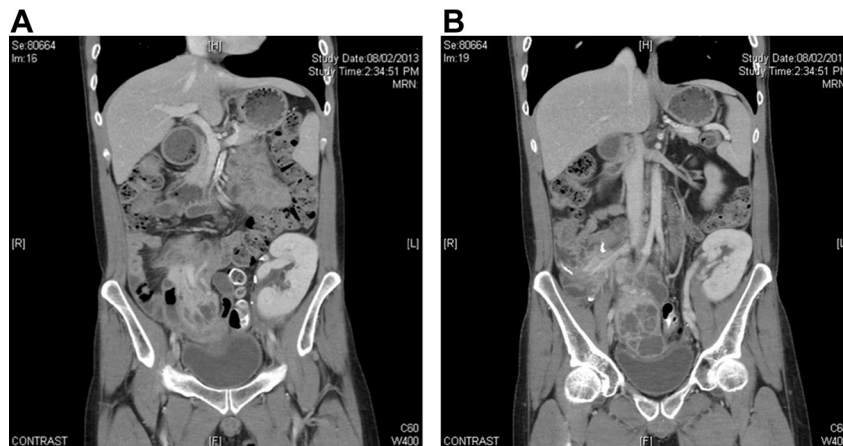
(A and B) A 4-cm cystic lesion in the body and tail of the pancreas with intact splenic artery on CT evaluation (5 months after transplantation).
